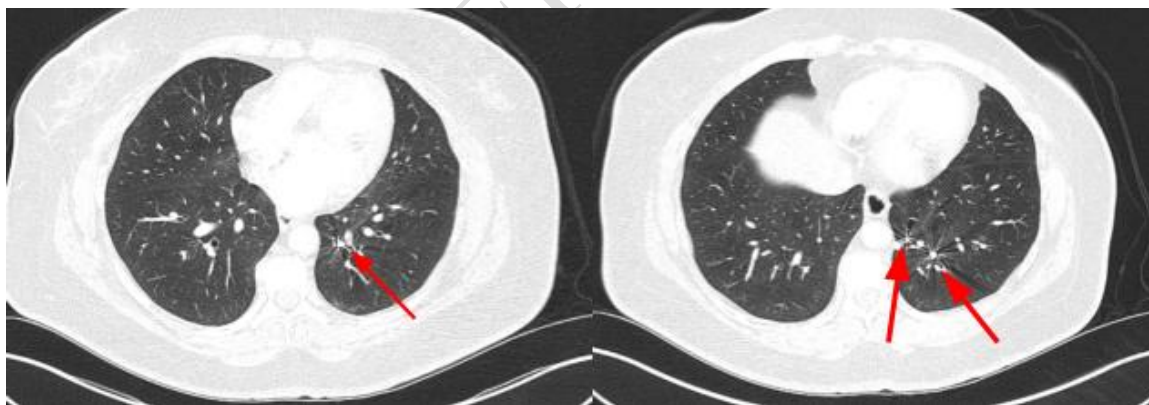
Follow-up chest CTA demonstrates coil embolization of the treated left lower-lobe PAVMs (arrows), without residual flow.
